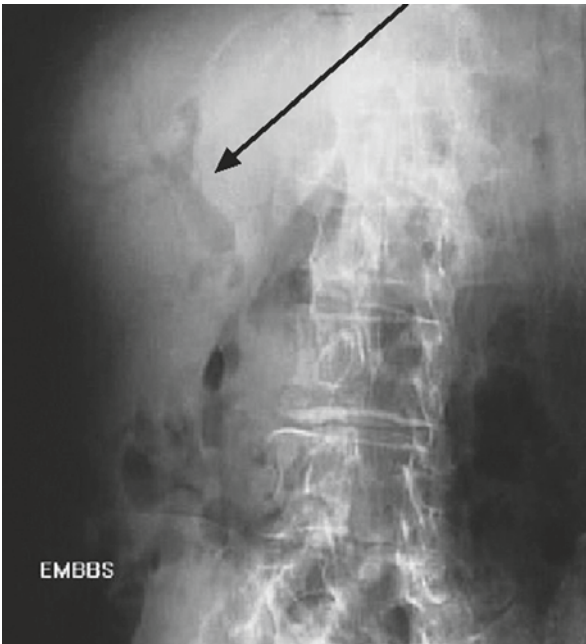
Abdominal X-ray: air in biliary tract (*arrow*)
